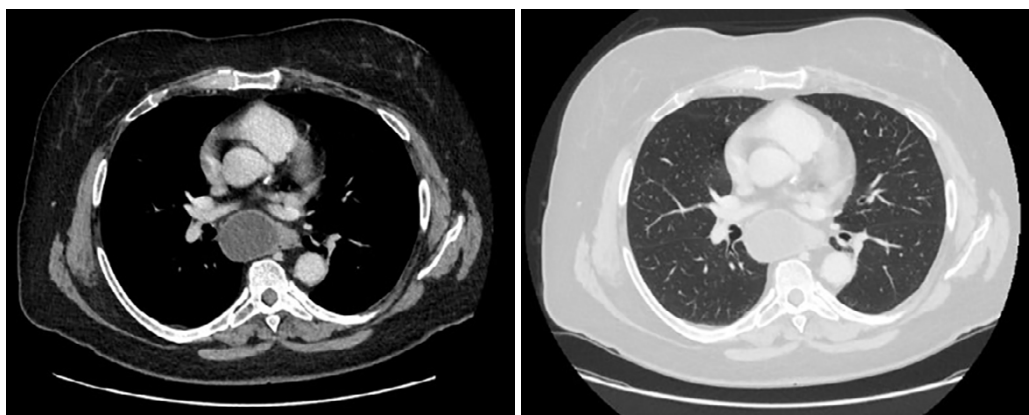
CT image showing enlarged station 7 lymph nodes with fluid attenuation and features of necrosis (post-biopsy).
